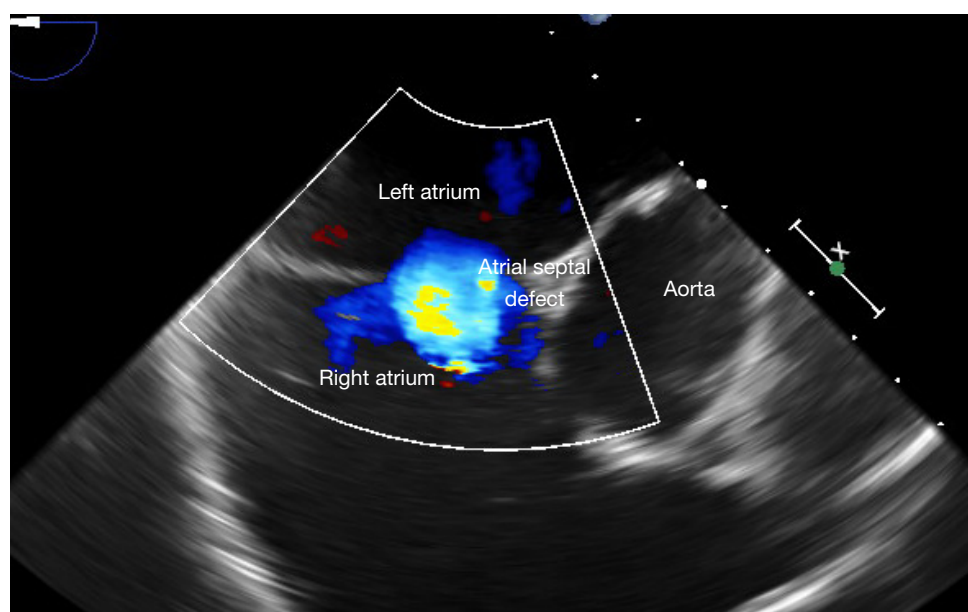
A two-dimensional transoesophageal echocardiogram (mid-oesophageal short axis view) with Doppler colour flow (blue), showing a left atrial to right atrial shunt, across a large secundum atrial septal defect.
